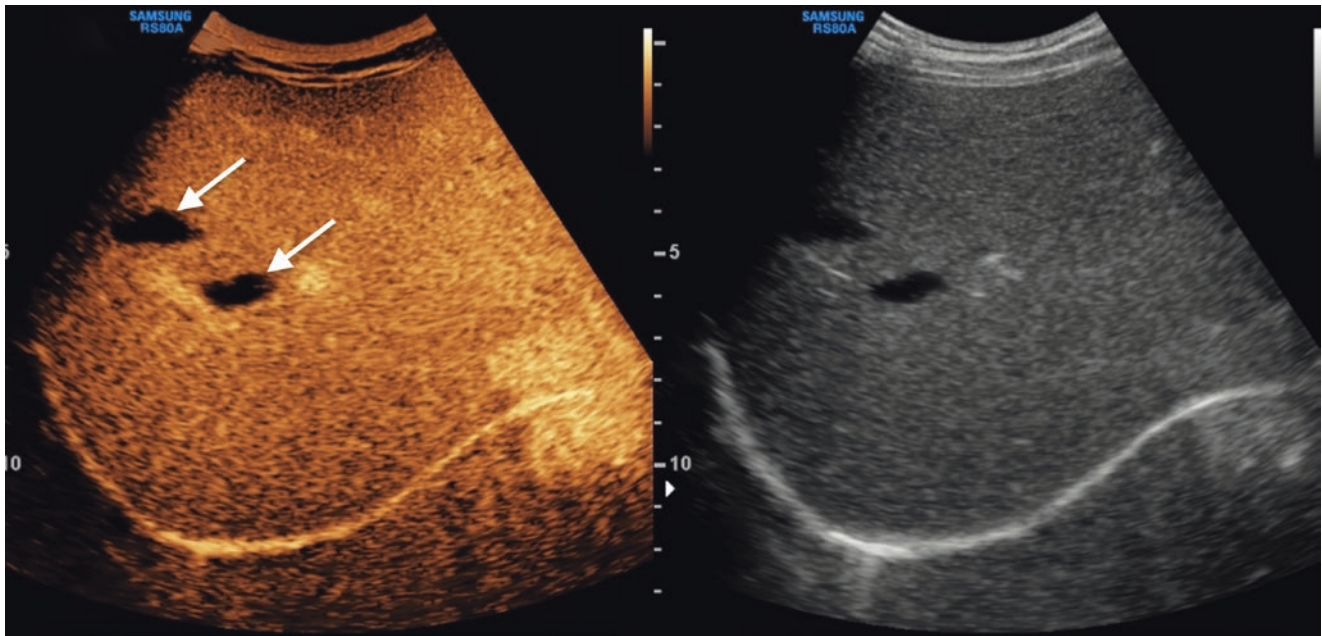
CEUS (left) and B-mode (right) ultrasound images show well-defined anechoic and non-enhanced lesion in the liver parenchyma consistent with post-traumatic bilomas (*arrows*)
